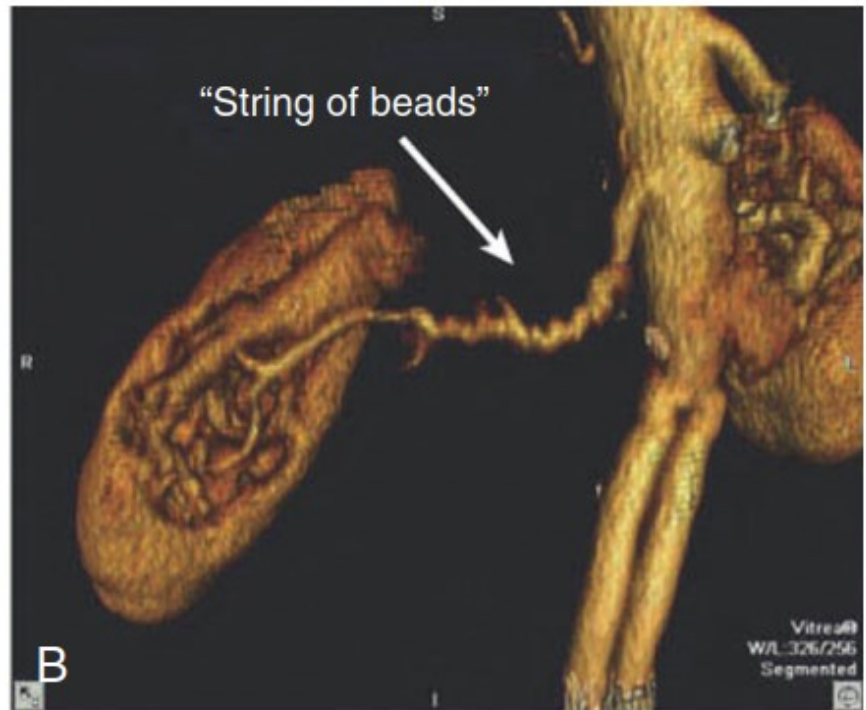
Computed tomography angiogram with three-dimensional reconstruction, showing a severe proximal atherosclerotic stenosis of the right renal artery and mild stenosis of the left renal artery (A) and the classic “string-of-beads” lesion of fibromuscular dysplasia (bilateral in this patient) (B). (Courtesy Dr. Bart Domatch, Radiology Department, University of Texas Southwestern Medical Center, Dallas.)
